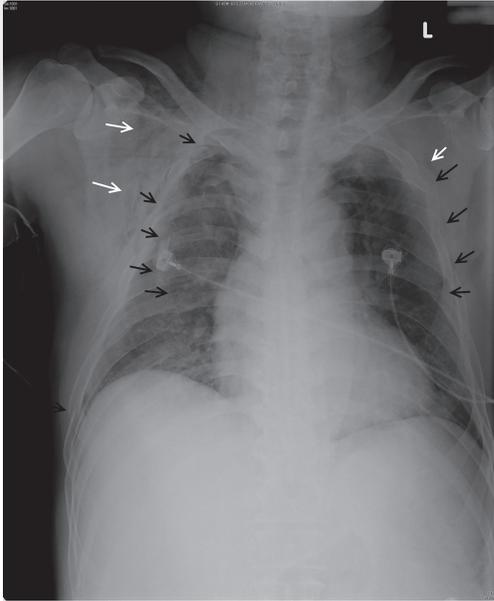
This chest X-ray shows multiple bilateral rib fractures with displacement (black arrows), bilateral subcutaneous emphysema (white arrows), and increased infiltration indicating pulmonary contusion in both lung fields.
